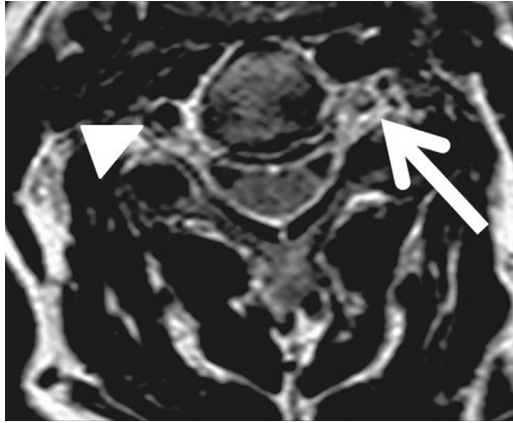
Axial T2-weighted image through the cervical spine demonstrates an abnormal lack of flow void in the left vertebral artery, which is high signal (arrow). The right vertebral artery (arrowhead) demonstrates a normal flow void.
